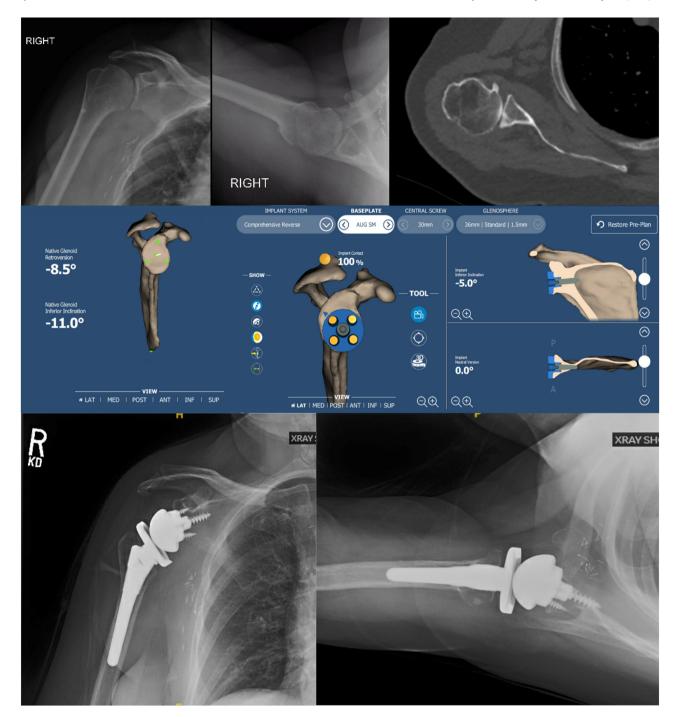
Preoperative radiographs, computed tomography (CT) scan, 3D planning, and postoperative radiographs for a patient who underwent rTSA with high-side reaming and a small glenoid augment for treatment of glenohumeral arthritis with B2 glenoid morphology and 8.5° of retroversion. *rTSA*, reverse total shoulder arthroplasty.
